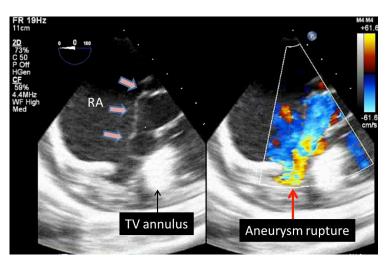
Transesophageal echocardiogram: color compare image showing an enlarged right atrium, aneurysmal tissue superior to the tricuspid valve annulus, and color Doppler indicating high-velocity shunting from the aneurysm toward the right atrial appendage. RA-right atrium, wide arrows indicate non-coronary sinus of Valsalva aneurysm.
